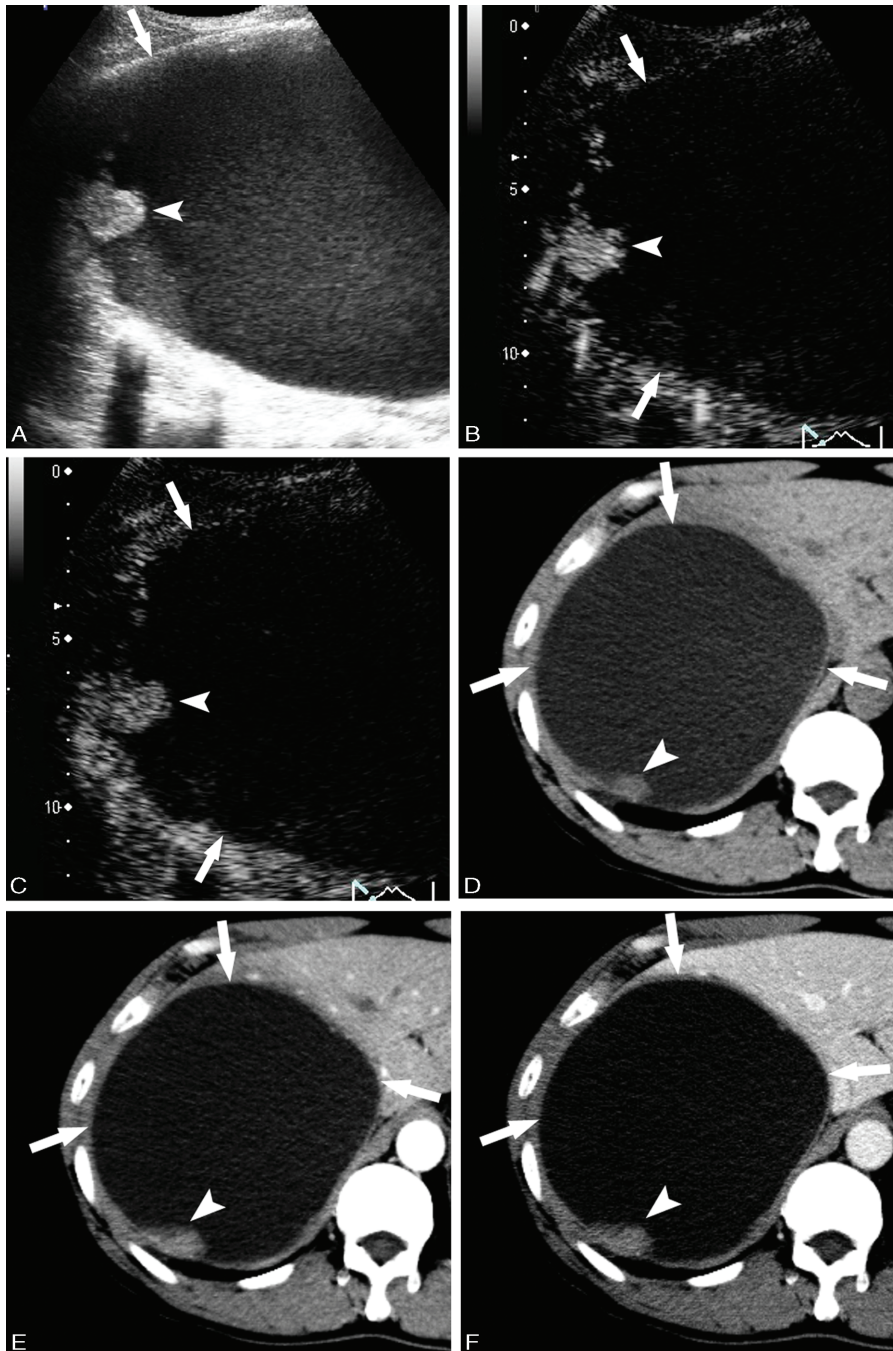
Primary hepatic neuroendocrine tumor in a 59-year-old man (case 6). A, Conventional B-mode ultrasonography revealed a monolocular lesion (arrow) with a wall nodule (arrow head) 17.6 cm in diameter. B, C, Contrast-enhanced ultrasonography obtained at 18 s (B) and 45 s (C) showed hyperenhancement in the wall nodule (arrow head) in the arterial phase (B) and hypoenhancement in the portal venous phase (C). CT revealed a cystic lesion (arrow) with a wall nodule (arrow head) in the plain phase (D) and hyperenhancement in the wall nodule (arrow head) in the arterial phase (E) and hypoenhancement in the portal venous phase (F).
